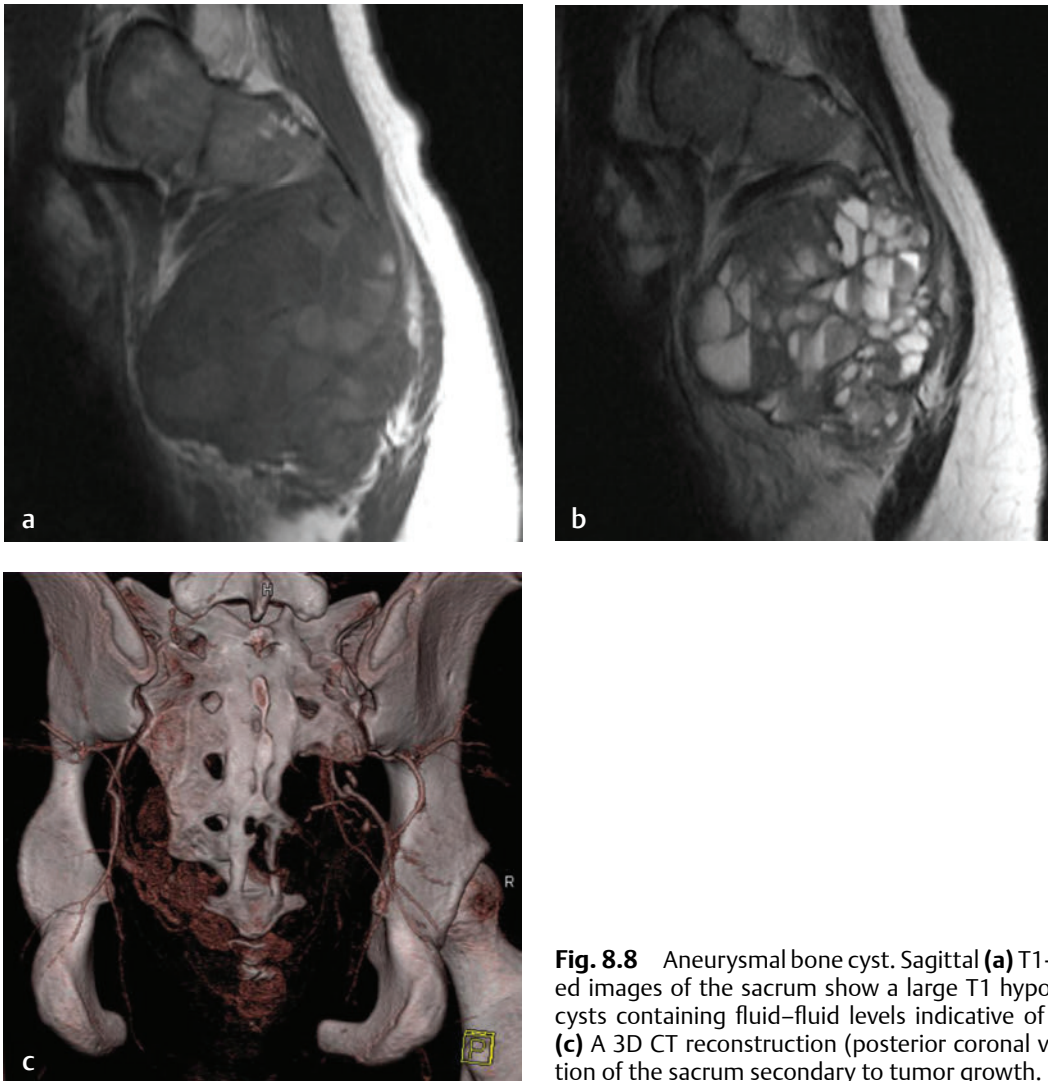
Aneurysmal bone cyst. Sagittal (a) T1-weighted and (b) T2-weighted images of the sacrum show a large T1 hypointense tumor with multiple cysts containing fluid–fluid levels indicative of blood breakdown products. (c) A 3D CT reconstruction (posterior coronal view) shows osseous destruction of the sacrum secondary to tumor growth.
